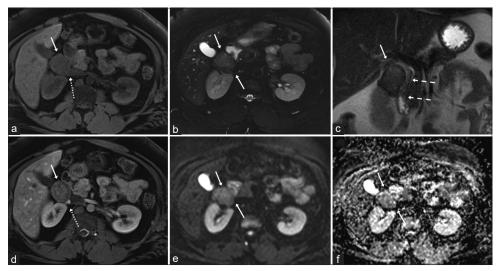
A 31-year-old male presented with the right-sided abdominal pain. (a) Axial T1-weighted, (b) axial and (c) coronal T2-weighted pre-contrast MRI images, and (d) axial T-1 fast-saturated post-contrast MRI images demonstrate a mildly enhancing right upper quadrant mass (solid arrows) abutting the right kidney, liver, duodenum (dashed arrows, c), and right renal vein (dotted arrows, a and d). (e) Diffusionweighted imaging MRI image demonstrates heterogeneous signal of the mass and (f) apparent diffusion coefficient map shows no definite restricted diffusion.
